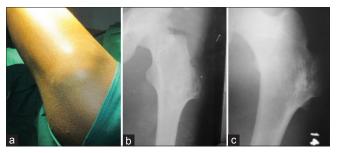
(a) Clinical picture of the lesion over lateral aspect of proximal thigh of left side, (b) X-ray picture in anteroposterior view, (c) X-ray picture in lateral view
